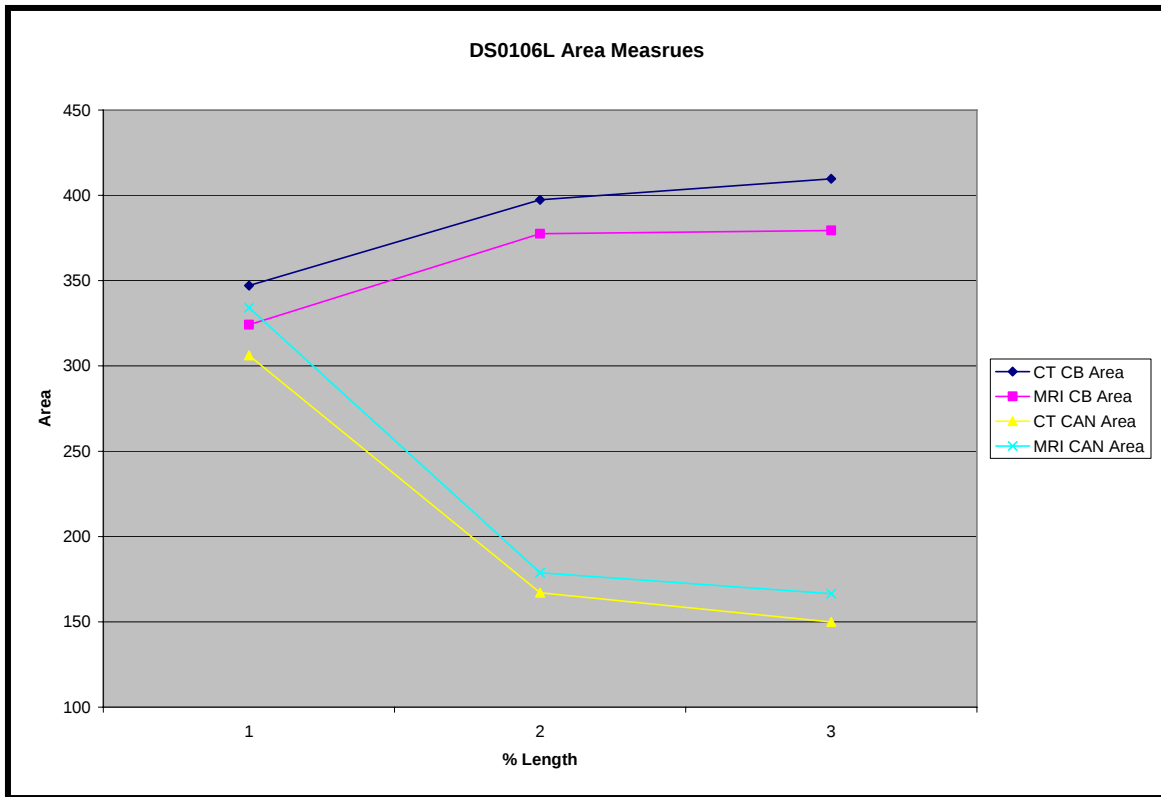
Graph of CT and MRI estimated cortical bone area (CB Area) and medullary canal area (CAN Area) for Study 1 bone DS0106L. Differences between CT and MRI data are statically different for each measurement location (see Table 2 and 3).
